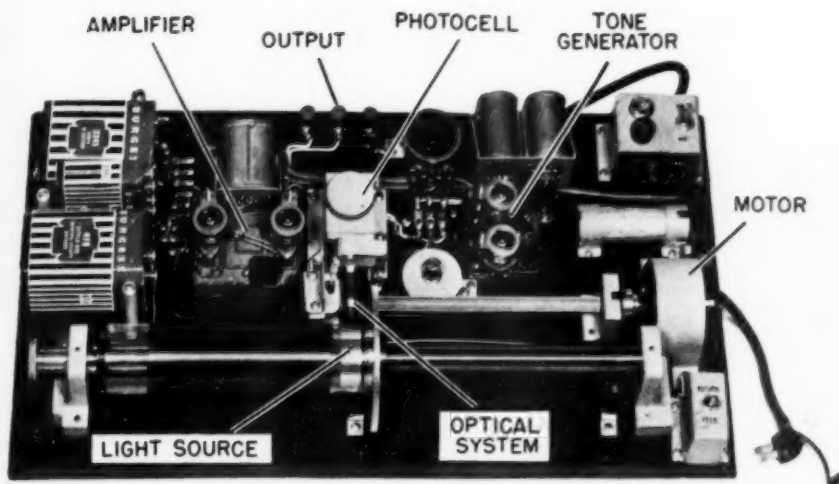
Roentgenographic facsimile transmitter.
